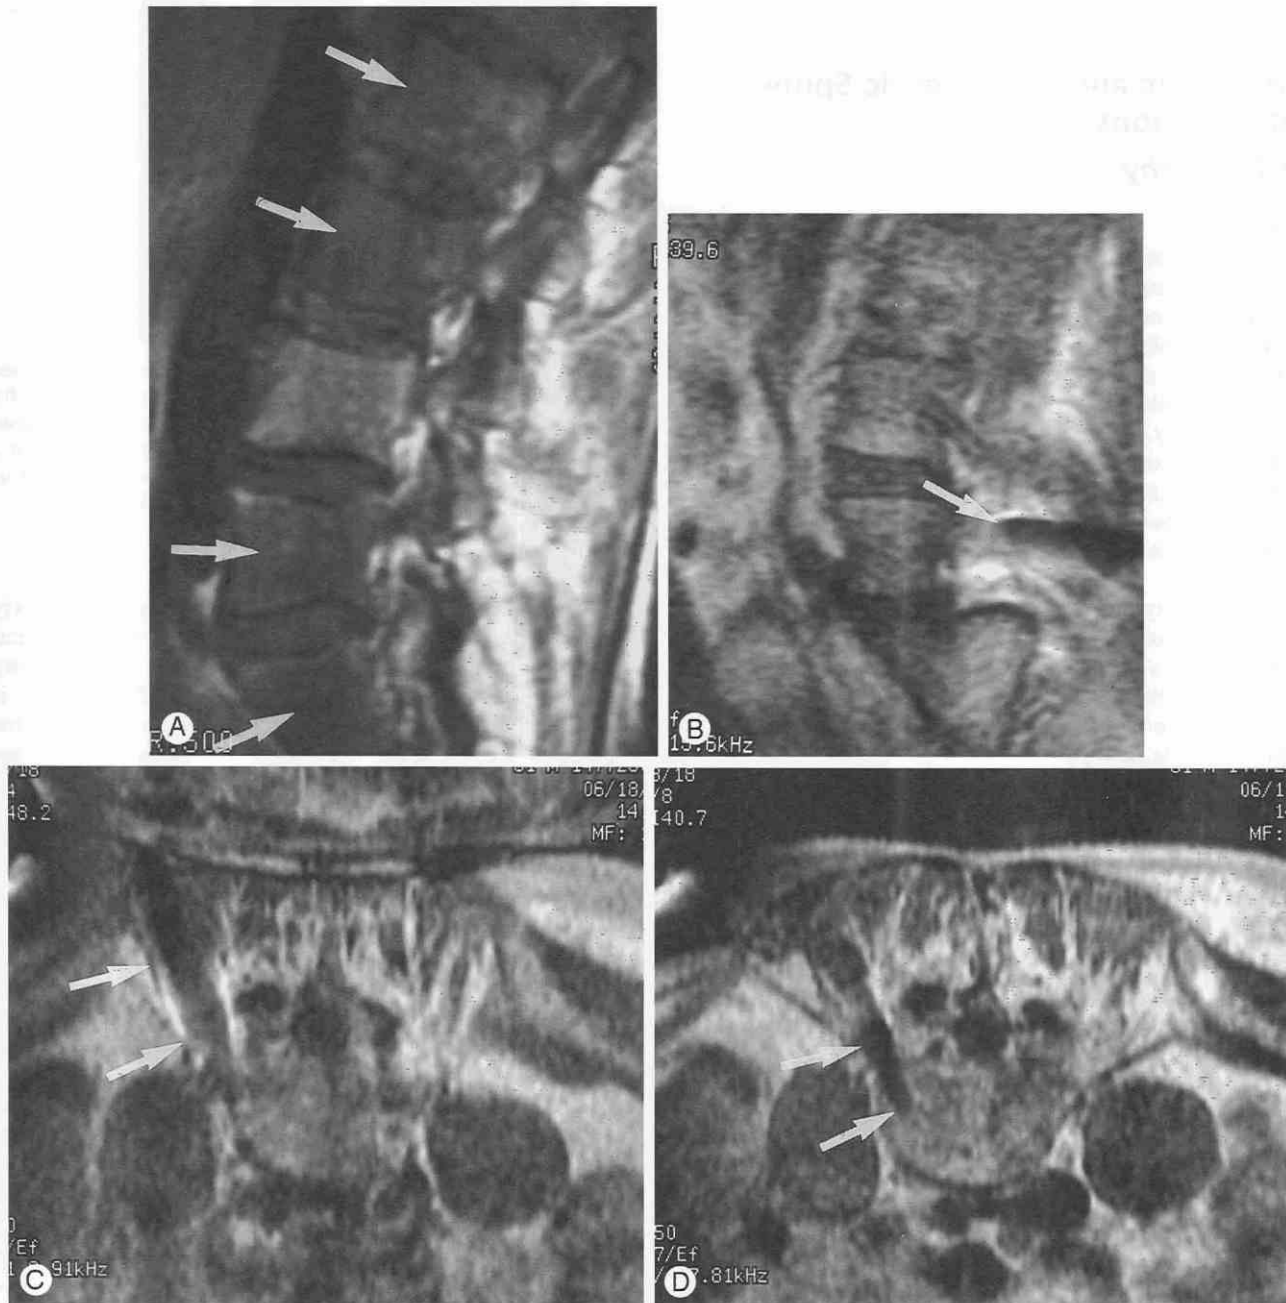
Bone marrow changes of unknown etiology. This potential abnormality was not visible on CT. A, Sagittal T1-weighted localizer image demonstrates patchy infiltration of the bone marrow in multiple lumbar vertebral bodies (arrows). B-D, Real-time axial images during left L5 transpediculate biopsy. Note susceptibility artifacts from needle. Cytologic diagnosis was negative for malignancy.
